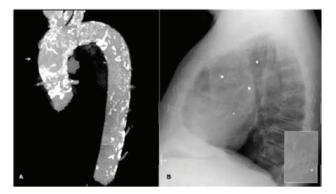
A. Computed tomography reconstruction showing the severely calcified thoracic aorta and the approach point (*arrow*). Lateral chest x-ray showing the implanted prosthesis (*) and the calcified aorta (*arrows*).
